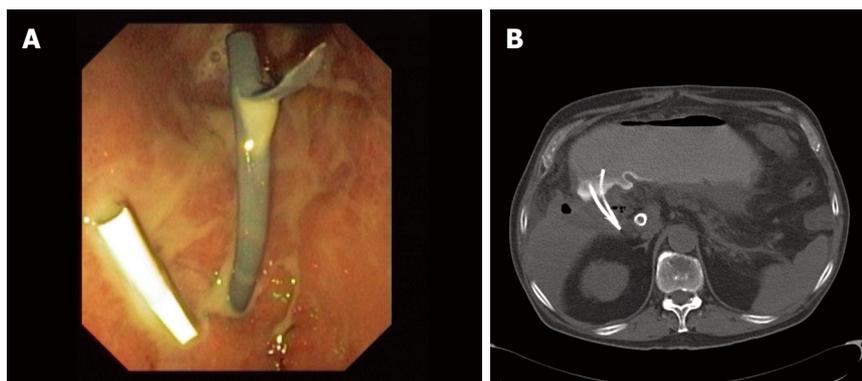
Two straight stents of 8.5 fr draining purulent material between the gallbladder and the gastric antrum; A: From the gallbladder to the gastric antrum; B: CT-scan performed some days after the procedure showing the stents and bubbles of gas in the gallbladder fundus.
